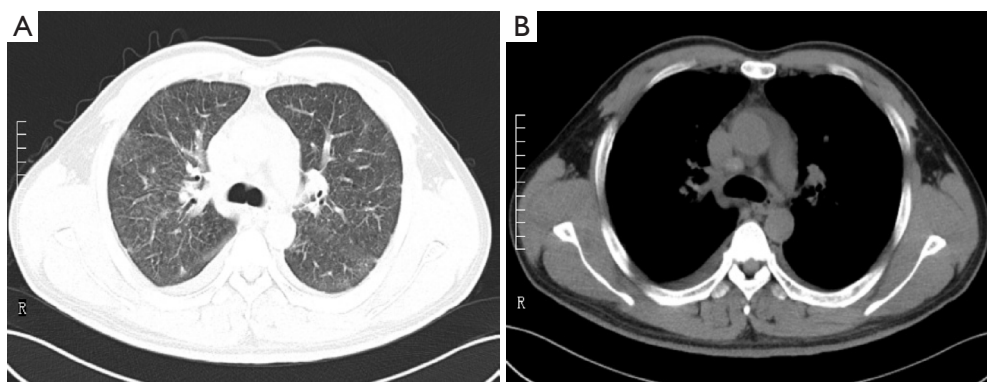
Chest computed tomography scan on July 15, 2020. (A) Diffuse lesions in both lungs. (B) Mediastinal lymph node enlargement.
